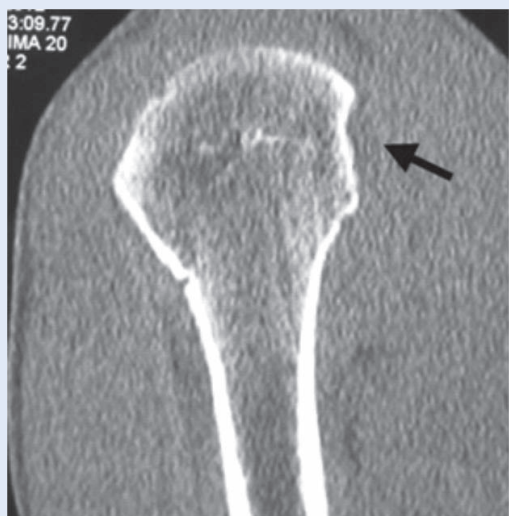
MRI showing the defect on the humeral head (Hill Sachs lesion)
